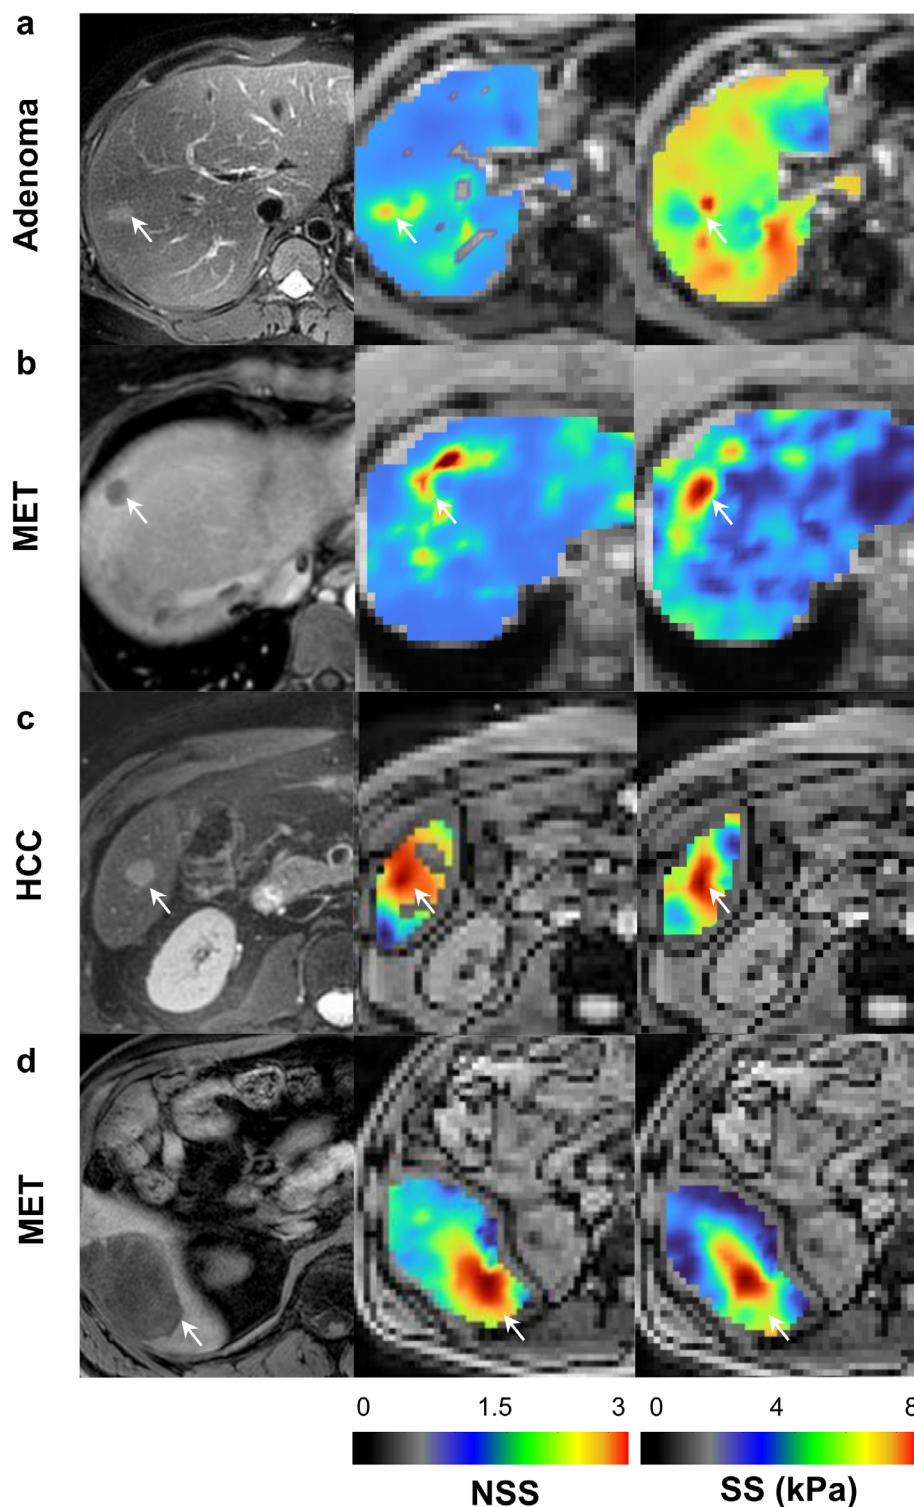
Intrinsic and extrinsic MRE results in four representative cases of benign and malignant liver tumors. Shown are maps of normalized SS and SS (kPa) along with MR images for anatomic orientation. (a) A 35-year-old woman with adenoma, (b) a 42-year-old woman with liver metastasis, (c) a 57-year-old man with a pathology-proven hepatocellular carcinoma (HCC) in the setting of a viral hepatitis B-induced liver cirrhosis, and (d) a 64-year-old man with a pathology-proven liver metastasis from a low-grade intestinal-type adenocarcinoma of the colon, all showed higher normalized SS (iMRE) and SS (eMRE at 60 Hz) than in the background liver tissue. NSS = normalized shear stiffness; SS = shear stiffness.
